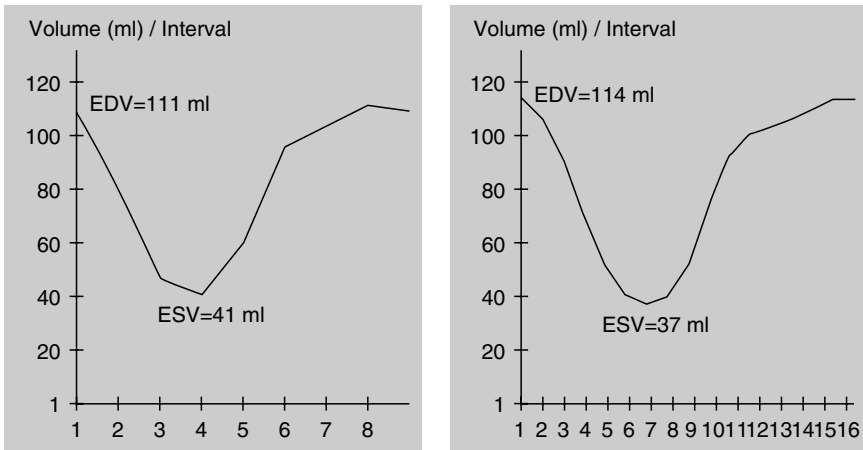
Quantitative time-volume curves derived from an 8-frame (left – EDV is at frame 1, ESV at frame 4) and a 16-frame (right – EDV is at frame 1, ESV at frame 7) gated SPECT acquisition. Note the larger dynamic range of the 16-frame measurements.
